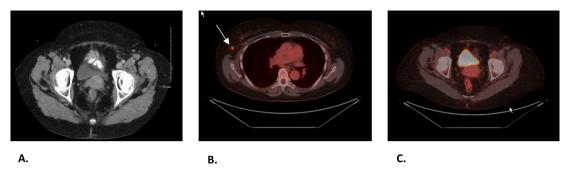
A. Computed tomography (CT) noting a normal appearing uterus and pelvis without evidence of gynecologic malignancy. B. Fluorodeoxyglucose (FDG)-positron emission tomography (PET)/CT noting FDG avid right axillary/breast mass. C. FDG PET/CT noting homogenous mild FDG update in the uterus without discrete focal abnormalities to suspect primary malignancy.
